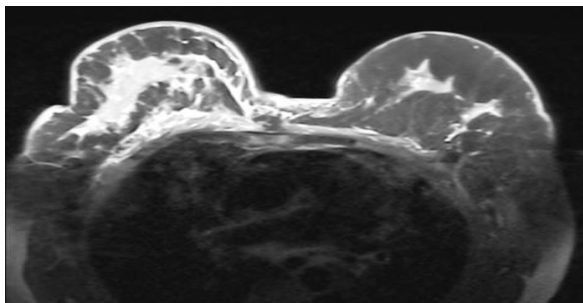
On MRI post-contrast, branching and linear enhancement with an irregular shape is seen.
